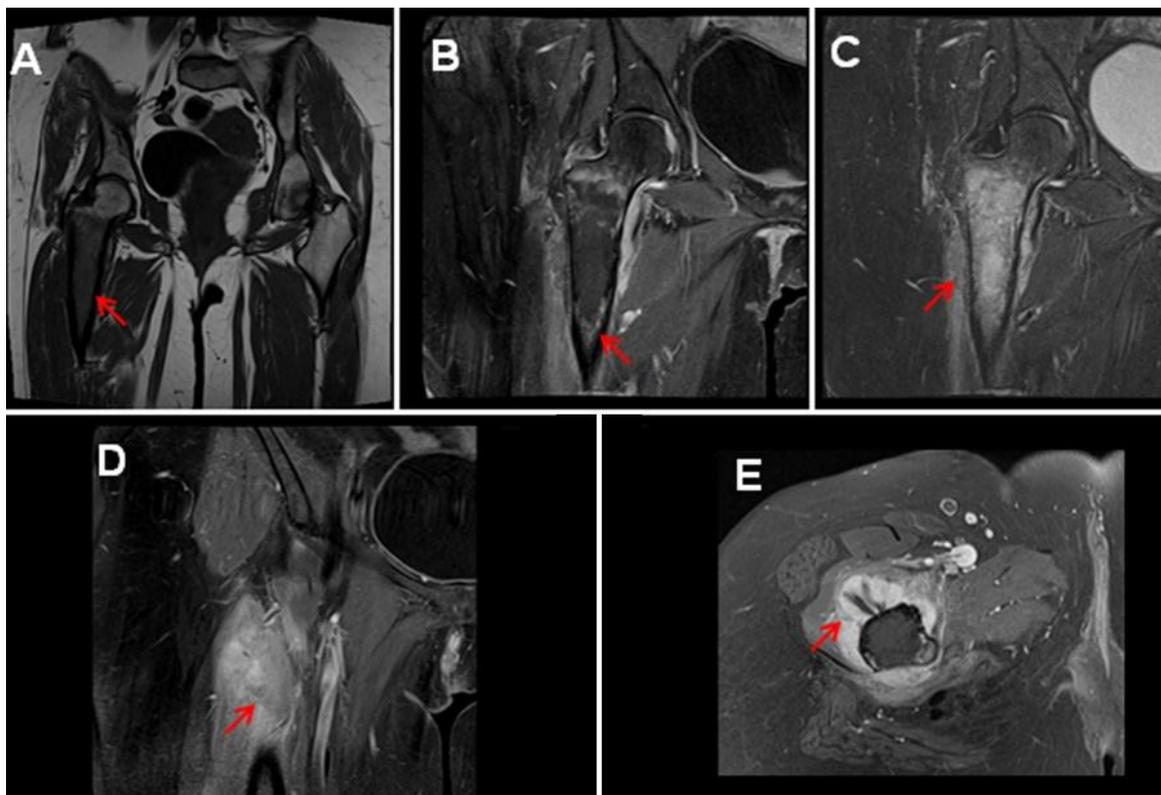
43 year old female with malignant phyllodes tumor. Contrast enhanced MRI of the right femur (Siemens Avanto 1.5 tesla)
